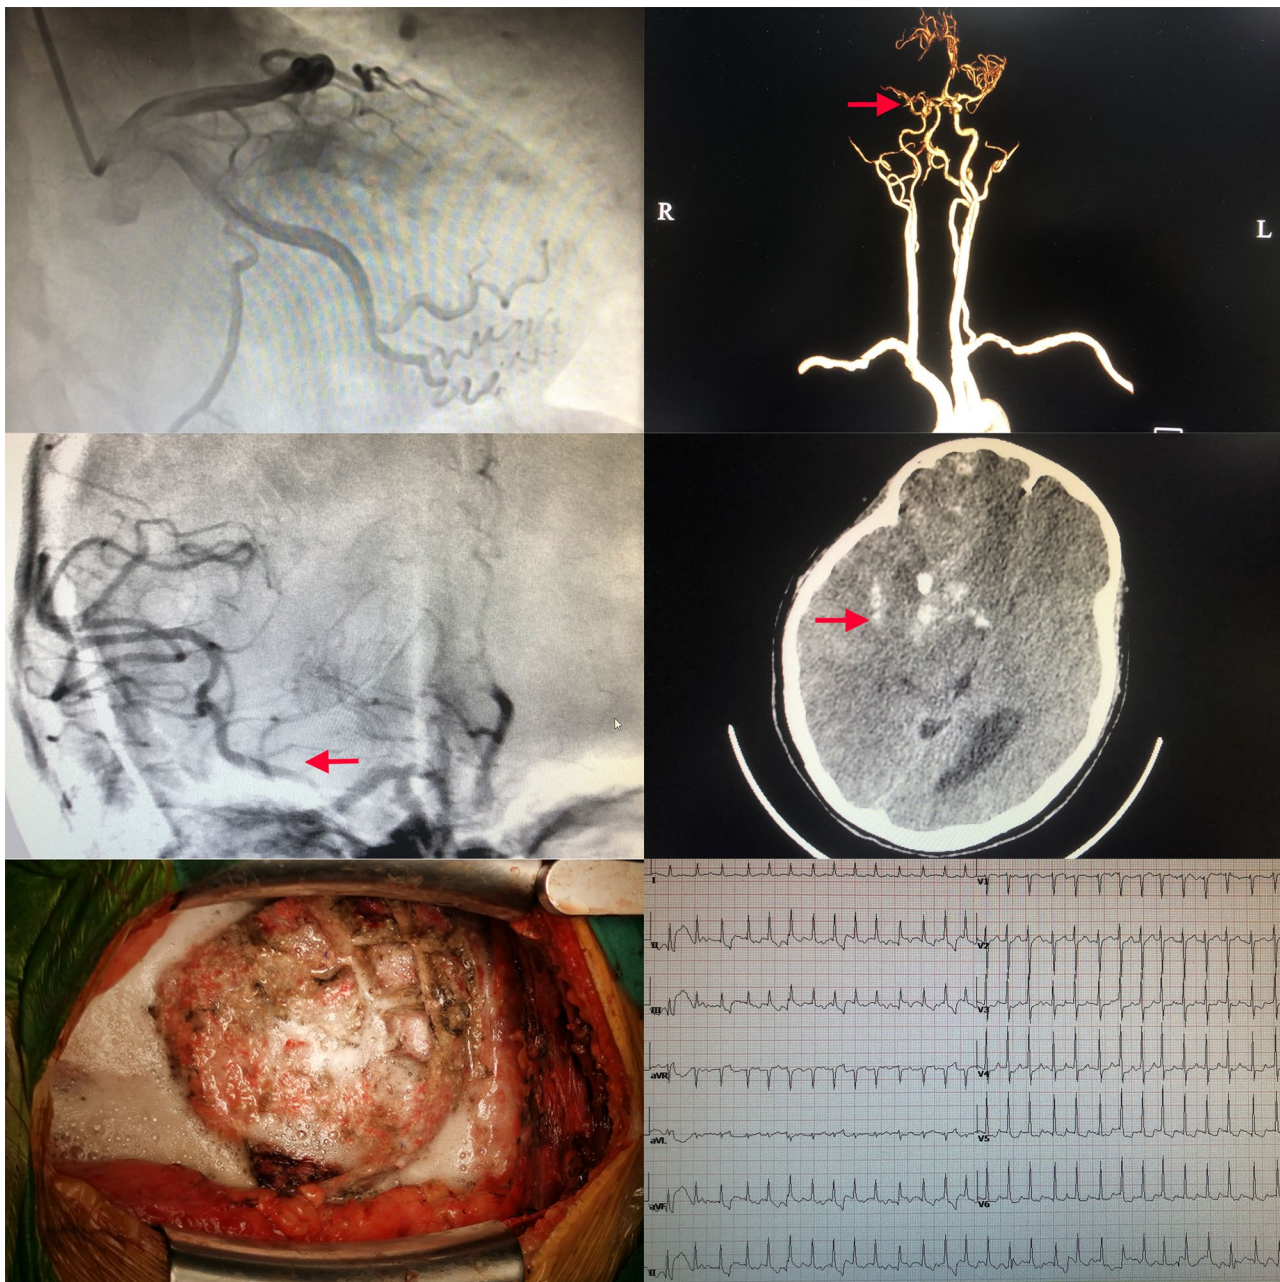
Fatal cerebral thrombosis after pericardiectomy. Preoperative normal coronary artery radiography (Top-left). The embolism of the right middle cerebral artery (Top-right). Complete recanalization of the thrombosed vessel (Middle-left). Progressive cerebral image (Middle-right). The nonpliable pericardium (Lower-left). Postoperative atrial fibrillation and rapid ventricular rates (Lower-right)
